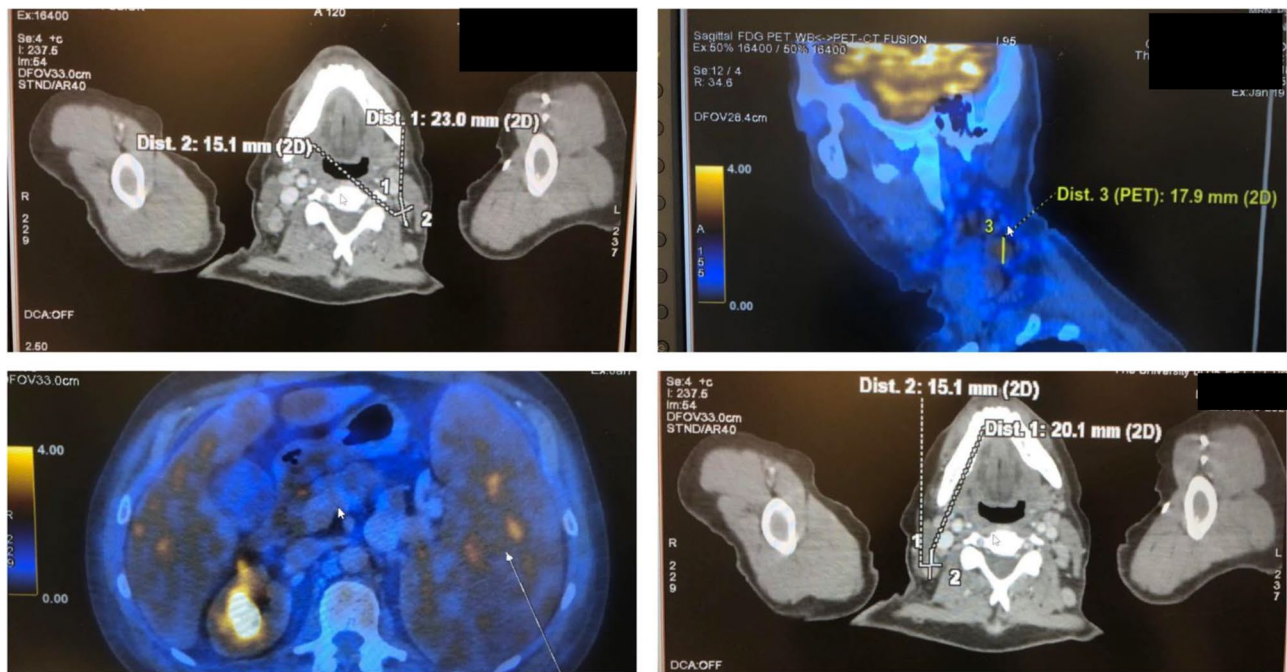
PET-CT findings of the patient
